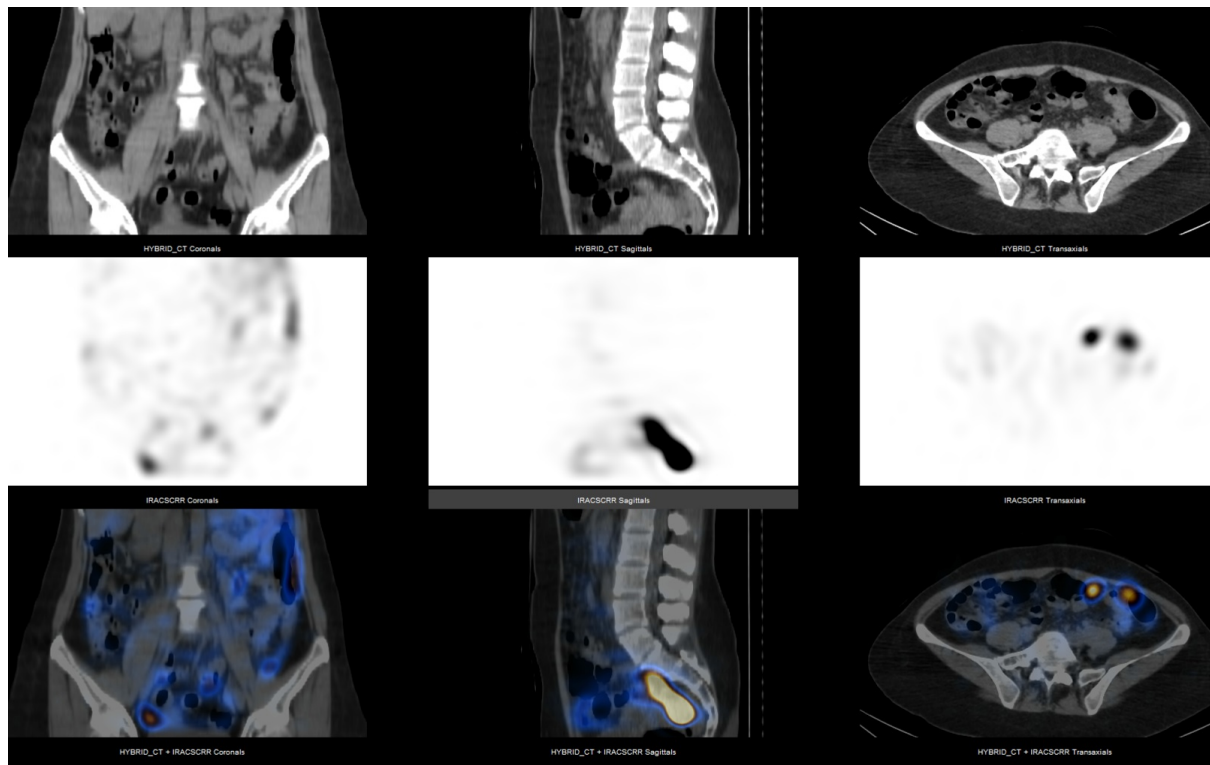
Planar and SPECT imaging of Patient 3 over coronal, sagittal and axial planes depicting dispersion of radioactivity both anterograde and retrograde from the SF injection site.
